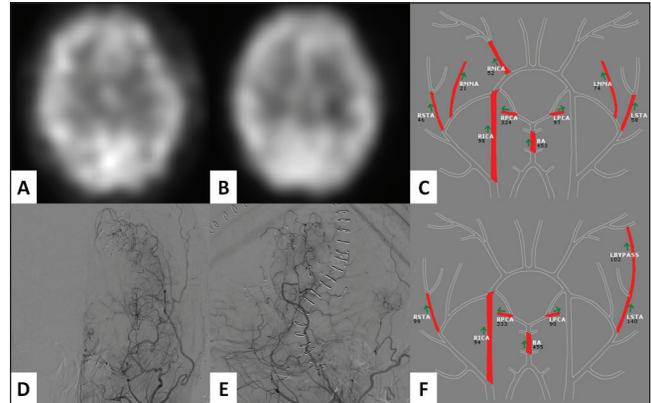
Same patient as in Figures 1 and 2. Brain SPECT at baseline (A) and after acetazolamide challenge (B) demonstrate perfusion asymmetry favoring the right hemisphere, significantly worse after acetazolamide challenge. This is indicative of poor CVR in the left hemisphere. Baseline NOVA Qmra (C). Arrows depict direction of blood flow, while numbers indicate corresponding flow rate in mL/min. Anteroposterior (D) and lateral (E) projection DSA of the left CCA, following combined direct-indirect surgical revascularization, reveals a patent STA-MCA bypass graft providing robust opacification of the MCA territory. Postoperative NOVA qMRA shows a very high flow rate of 102 mL/min in the bypass graft (F).
